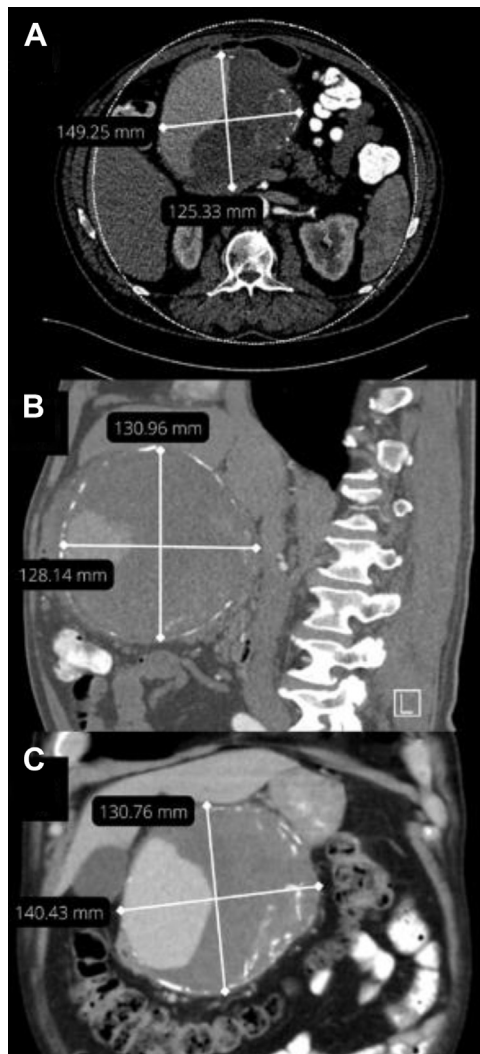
Preoperative computed tomography angiography images. (A) Preoperative transverse view of the aneurysm measuring 14.9 × 12.5 cm. (B) Preoperative sagittal view of the aneurysm measuring 13.1 × 12.8 cm. (C) Preoperative coronal view of the aneurysm measuring 14.0 × 13.1 cm.
